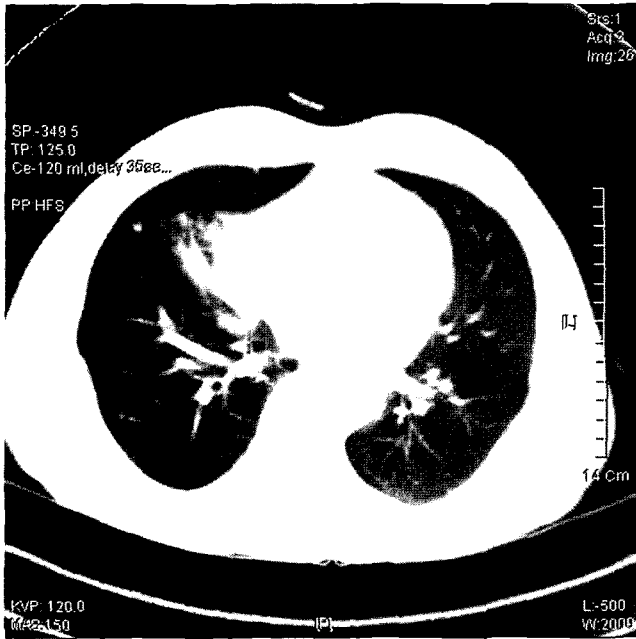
A chest CT scan showing lobulated contour of mass in the right middle lobe of medial segment, attached to mediastinal pleura.
